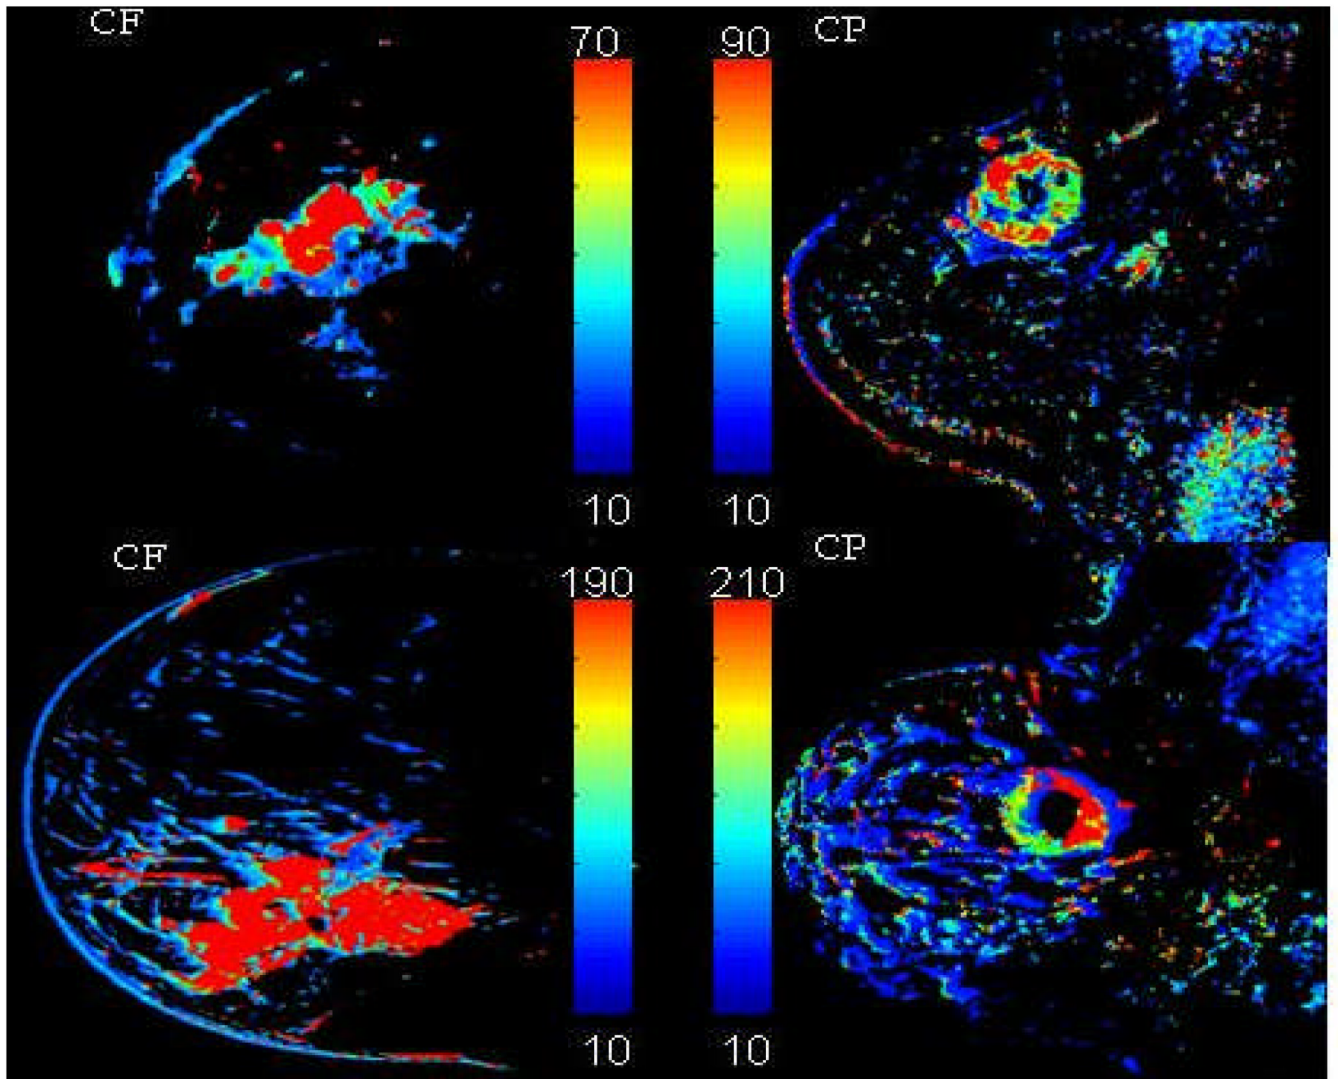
WiP maps generated from DCE-MRI that exemplify the type of enhancement noted in LABC patients: left column, centrifugal (CF), uniform enhancement from center to periphery; right column, centripetal (CP), inhomogeneous ring-type enhancement.
